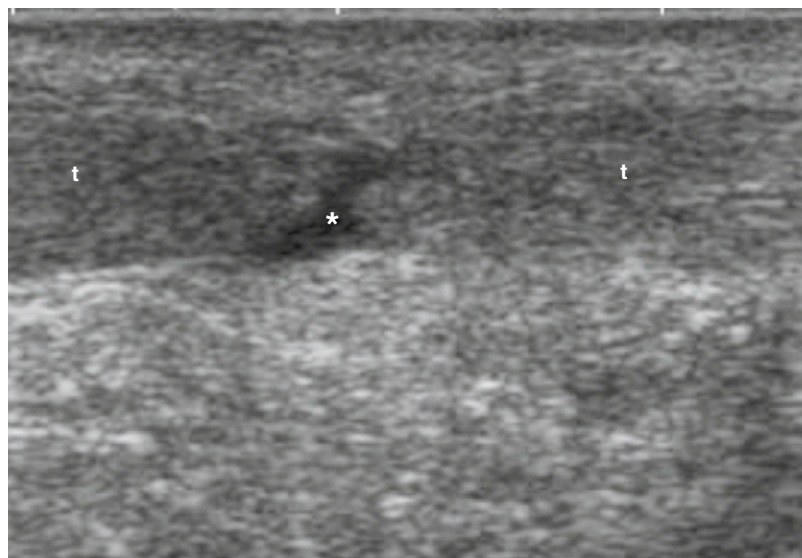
Ultrasound identified a tendon rupture, with a complete tear (star) of the Achilles tendon (t).
